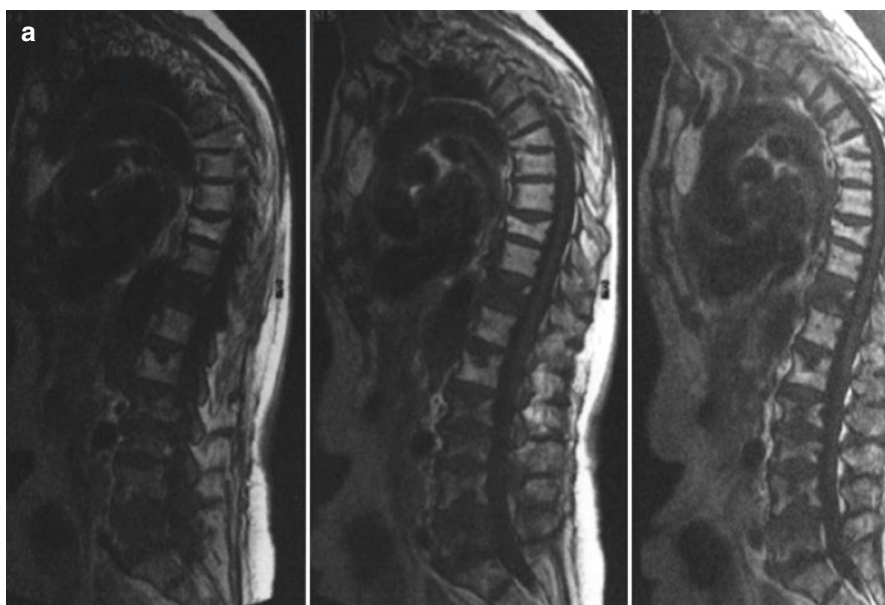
The sagittal T1W(a), STIR(b),T2W(c) MRI showed multiple osteoporotic vertebral compression fractures at thoracolumbar level with hyperintense signal on STIR (intra-spongious edema) in a 75-year-old affected female who was resistant to medical therapy and treated with one session of multilevel vertebroplasty (d)
